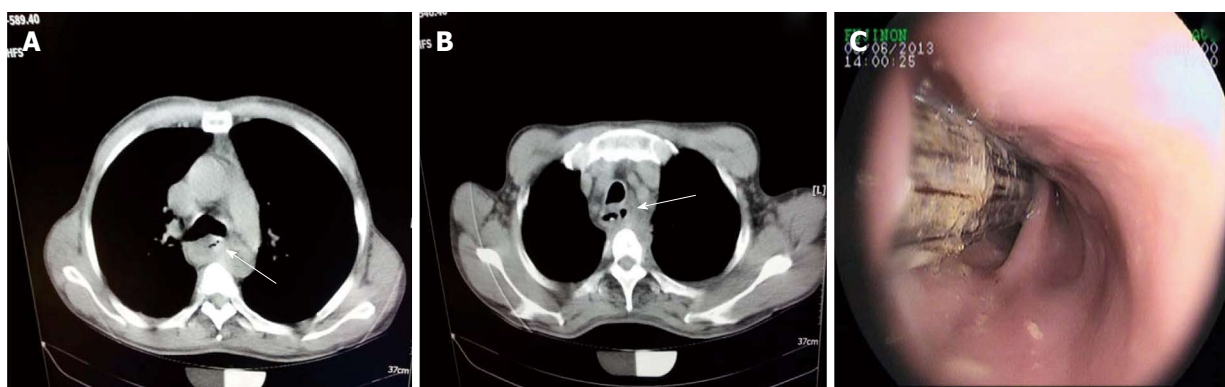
A long chopstick embedded in the esophageal wall. A and B: The roentgenograms showing the foreign body in the esophagus (arrow); C: Endoscopy showing the foreign body in the esophagus.
